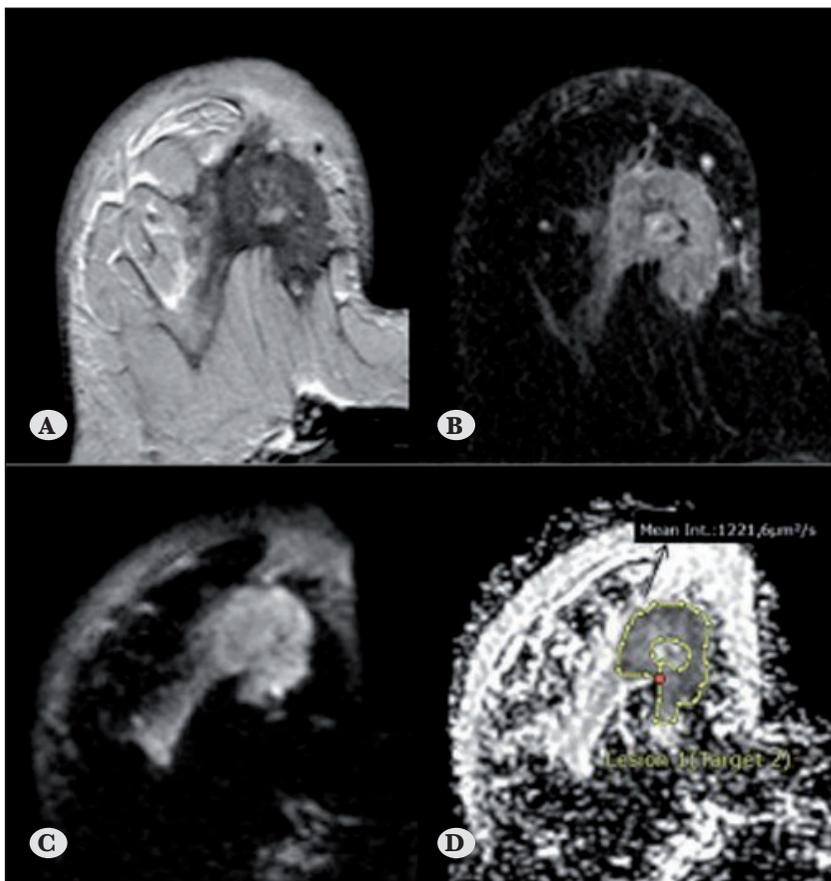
Axial T2W (A), T1a C+ (B), DWI (C) and ADCmap (D): ROI was measured particularly in the very vascular and solid areas of the tumor. In large lesions, the ROI was placed carefully. Areas of necrotic tissue and hemorrhagic component as identified from the morphologic and contrast-enhanced images were avoided.
